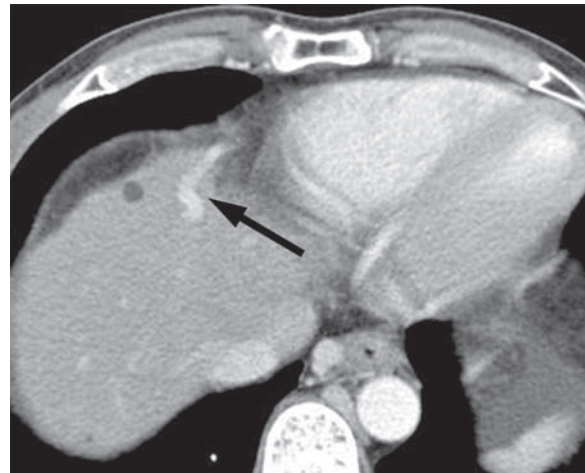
Superior vein of Sappey type intrahepatic portosystemic shunt in a 48-year-old man with liver cirrhosis. Portal venous phase CT scan shows a dilated left medial portal vein (arrow) arising from the surface of the medial segment of the left lobe and coursing toward the left anteriorly.
